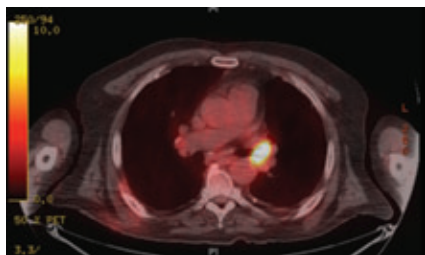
PET scan showing the hypermetabolic lesion in the left pulmonary hilar area with SUV of 18.8 that was not apparent on computed tomography after diagnosis.
